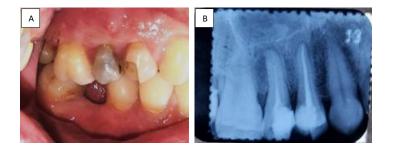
A. Clinical oral examination in tooth 25; B. Periapical radiograph of the last treatment in tooth 25.
